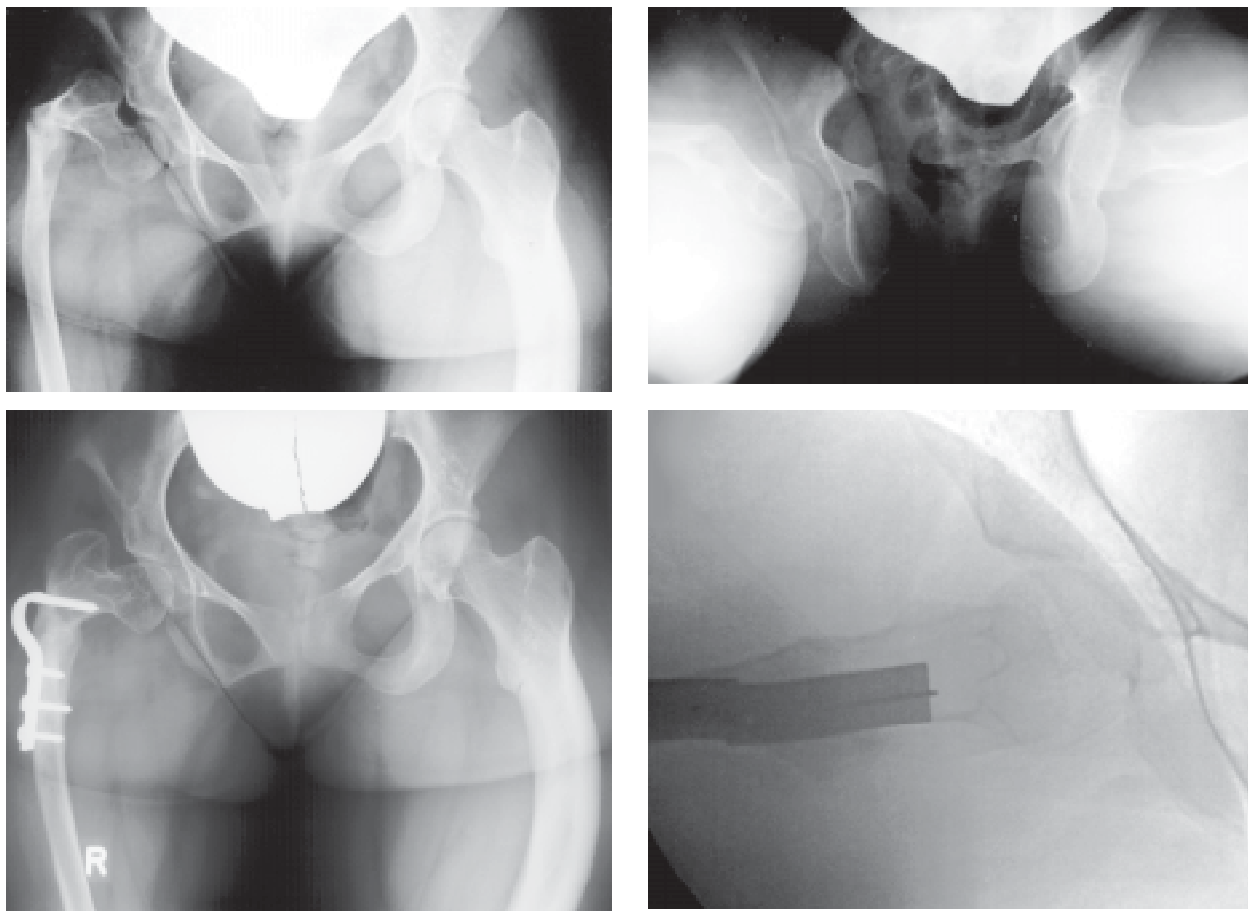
(a,b,c,d) X-ray anteroposterior (a) and lateral (b) view of proximal femur to show pseudarthrosis after non-treatment of fracture in a 16-year-old girl with type I osteogenesis imperfecta. After surgical correction of malposition and fixation with plate and screws, pseudarthrosis healed (c,d).
